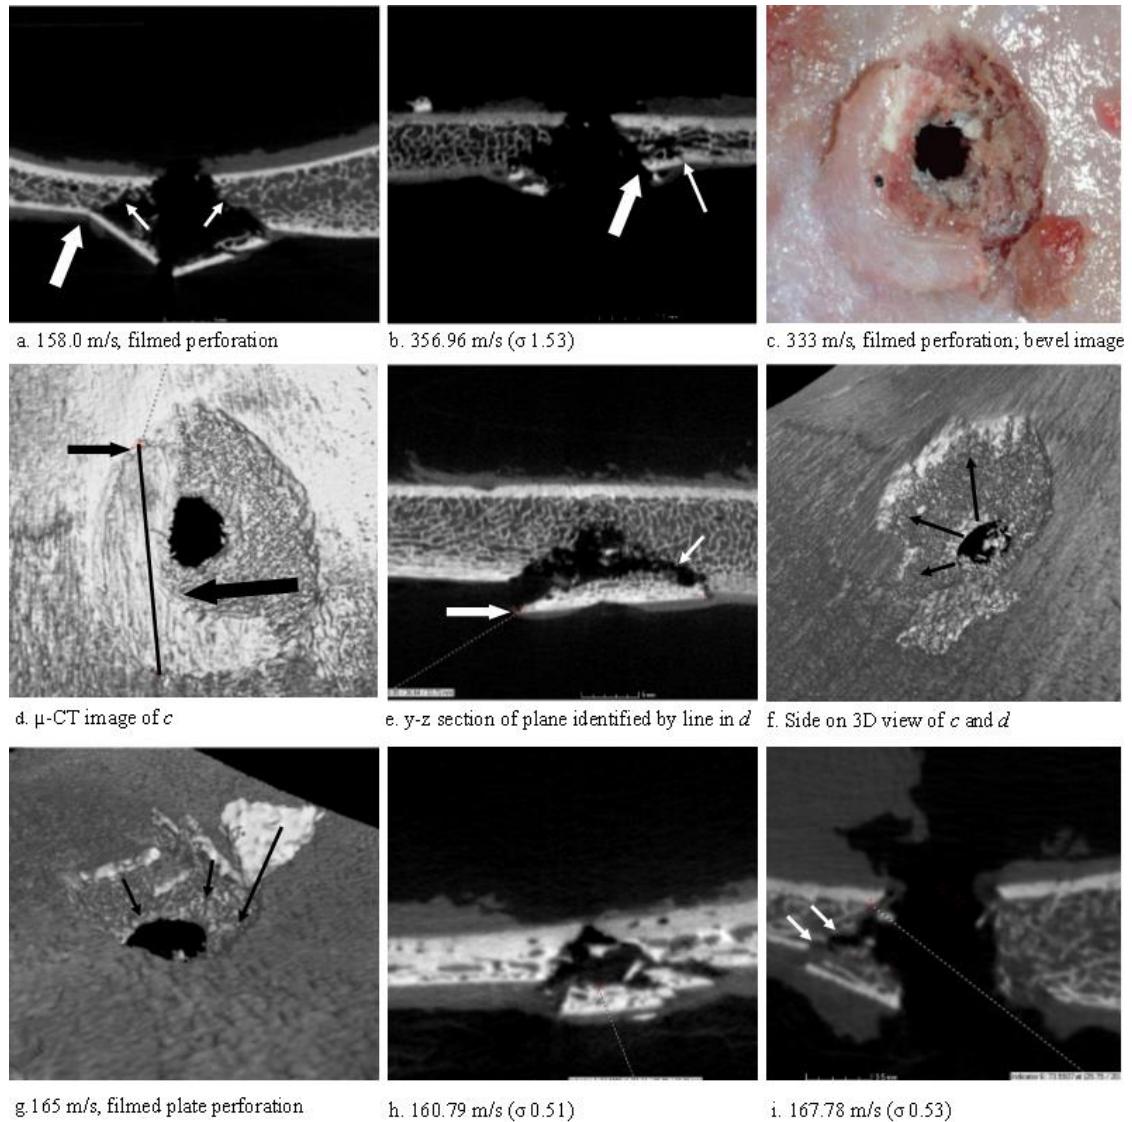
μ -CT images of inner cortical plate damage. a, x-z (transverse) cross-section of fragment cone with bevel concealed under fragments (arrows); large arrow marks the exit cortical fracture edge; b, accessory cortical fracture (thin arrow) outside the exit cortical fracture edge (thick arrow), y-z section. c. Photograph of C-shaped inner cortical plate fragment partially covering internal bevel after a 333 m/s perforation; d, μ -CT 3D view of fragment shown in c; black line shows plane of slice visible in e; e, y-z view of C-shaped fragment, viewed in direction of arrow shown in d; note the conoidal internal bevel above the fragment and the close approximation between bevel and fragment at right of image, with just over 1 mm separation in the region identified by the arrow; f, 3D view looking under C-shaped fragment in c-e; viewed from the right side, the internal bevel can be seen running underneath the fragment (arrows). g, 3D view looking into a conoidal wound from V_1 ; fragments moved in direction of arrows would partially re-form the floor of the wound; h. Marked conoidal fracture and counterpart fragments, y-z section; i; x-z section of bevelled edge (arrows) protected behind inner cortical plate fragment.
